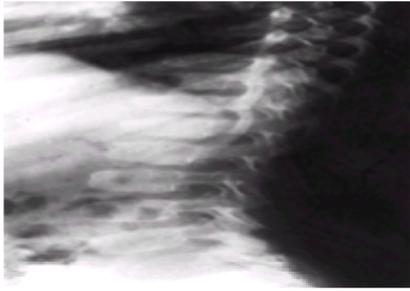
Lateral radiograph of the spine of a 6-year-old presenting with lumbar lordosis, difficulty in using the hands and limited walking ability. Note the characteristic beaking in vertebral bodies, particularly in the lower thoracic spine, in this child with spondyloepiphyseal dysplasia, which had also affected his father.
